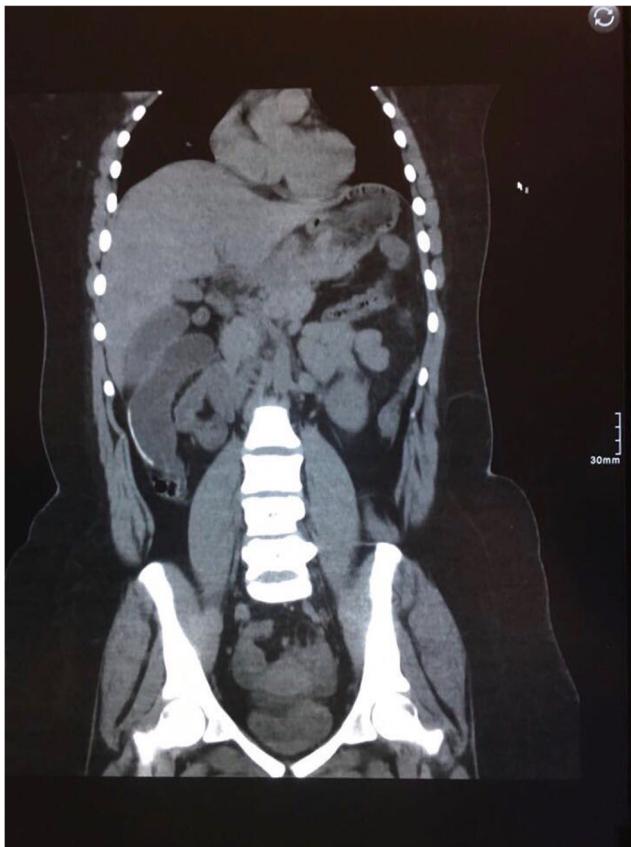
CT scan for patient with small bowel obstruction due to EIGB
